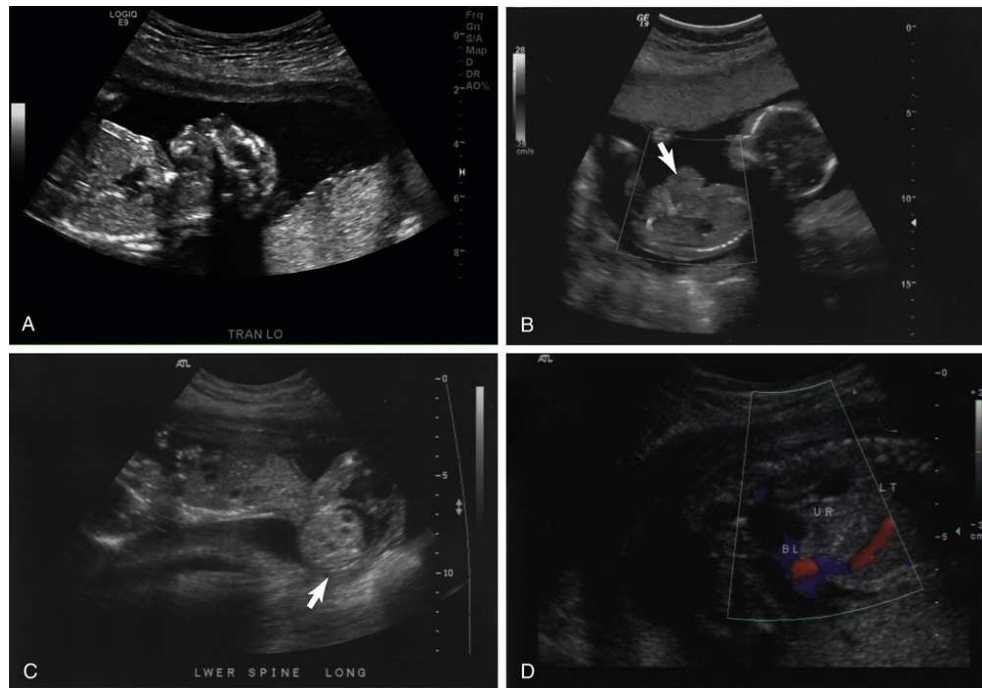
(A) Early second-trimester sonogram of the fetal facial profile showing anencephaly. (B) Sagittal image of early second-trimester fetus showing gastroschisis. (C) Sagittal image of second-trimester fetus showing sacral teratoma (*arrow*). (D) Sagittal image of left kidney showing hydronephrosis. A, Courtesy of Susanna Ovel RT, RDMS, RVT; B, courtesy Sharon Ballester, RT, RDMS; C, courtesy B. Alex Stewart, RT, RDMS.
